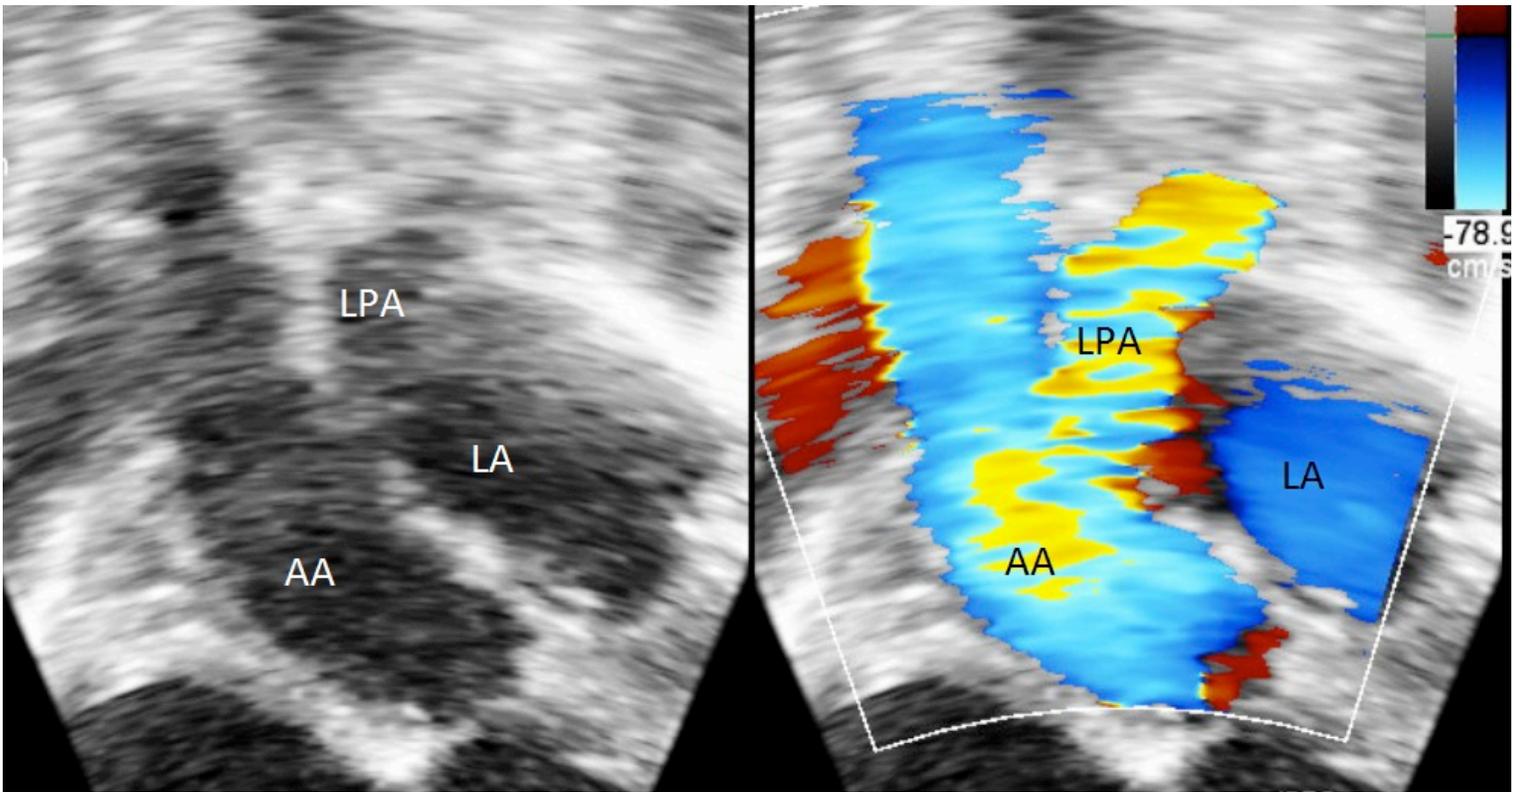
Pre-surgical echocardiogram with color flow, apical view with anterior angulation, reveals ascending aorta giving rise to left pulmonary artery. AA- Ascending aorta, LPA- Left Pulmonary Artery, LA- Left Atrium.
